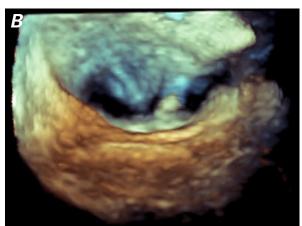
A) Intraoperative transesophageal echocardiogram
